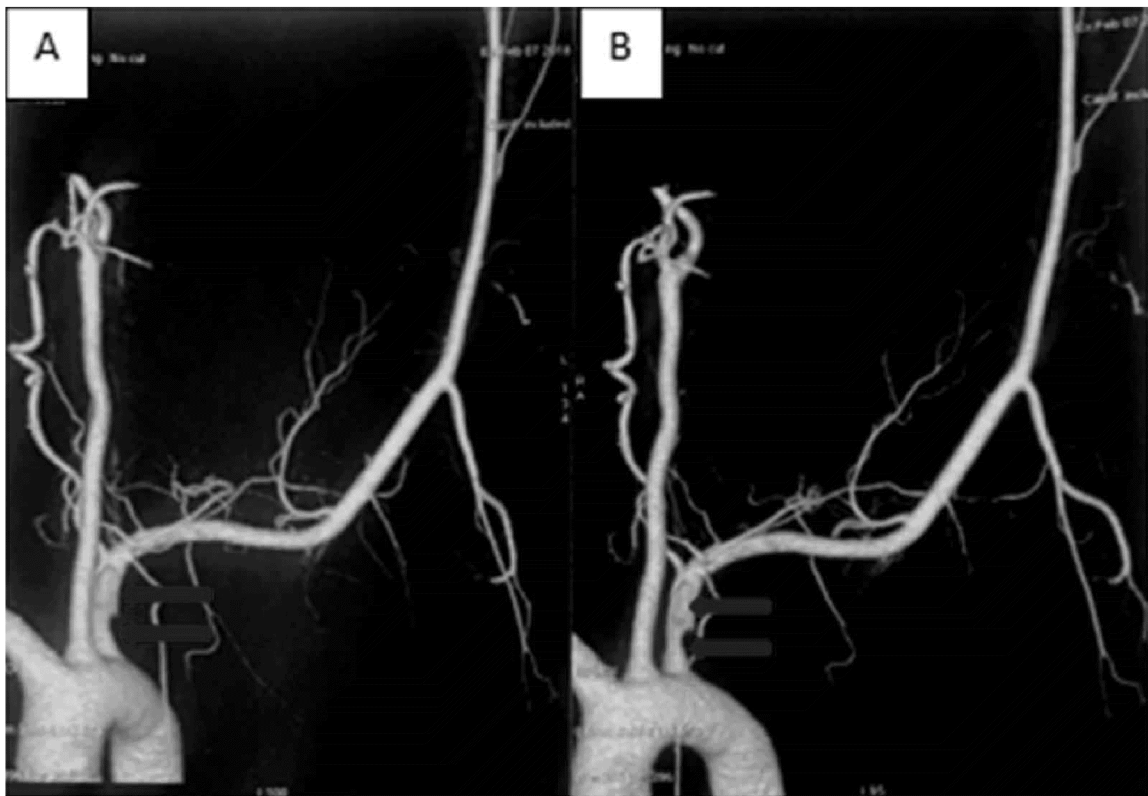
Left subclavian artery computed tomography angiogram showing partially occluded filling defect in the ostio-proximal segment and thrombus filling the lumen (red arrows).
